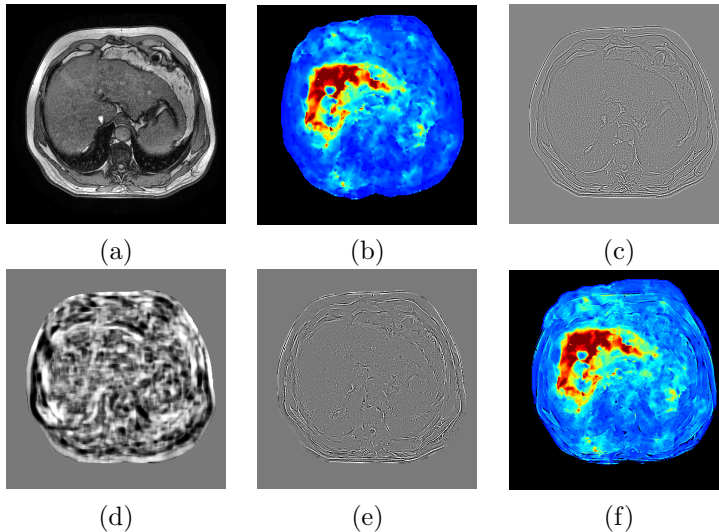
(a): MRI image; (b) expanded MRE image; (c): spatial details  $\delta$ ; (d) injection gain  $\mathbf{G}$ ; (e) product of injection gain and spatial details  $\mathbf{G} \cdot \delta$ , (f) fused image.
